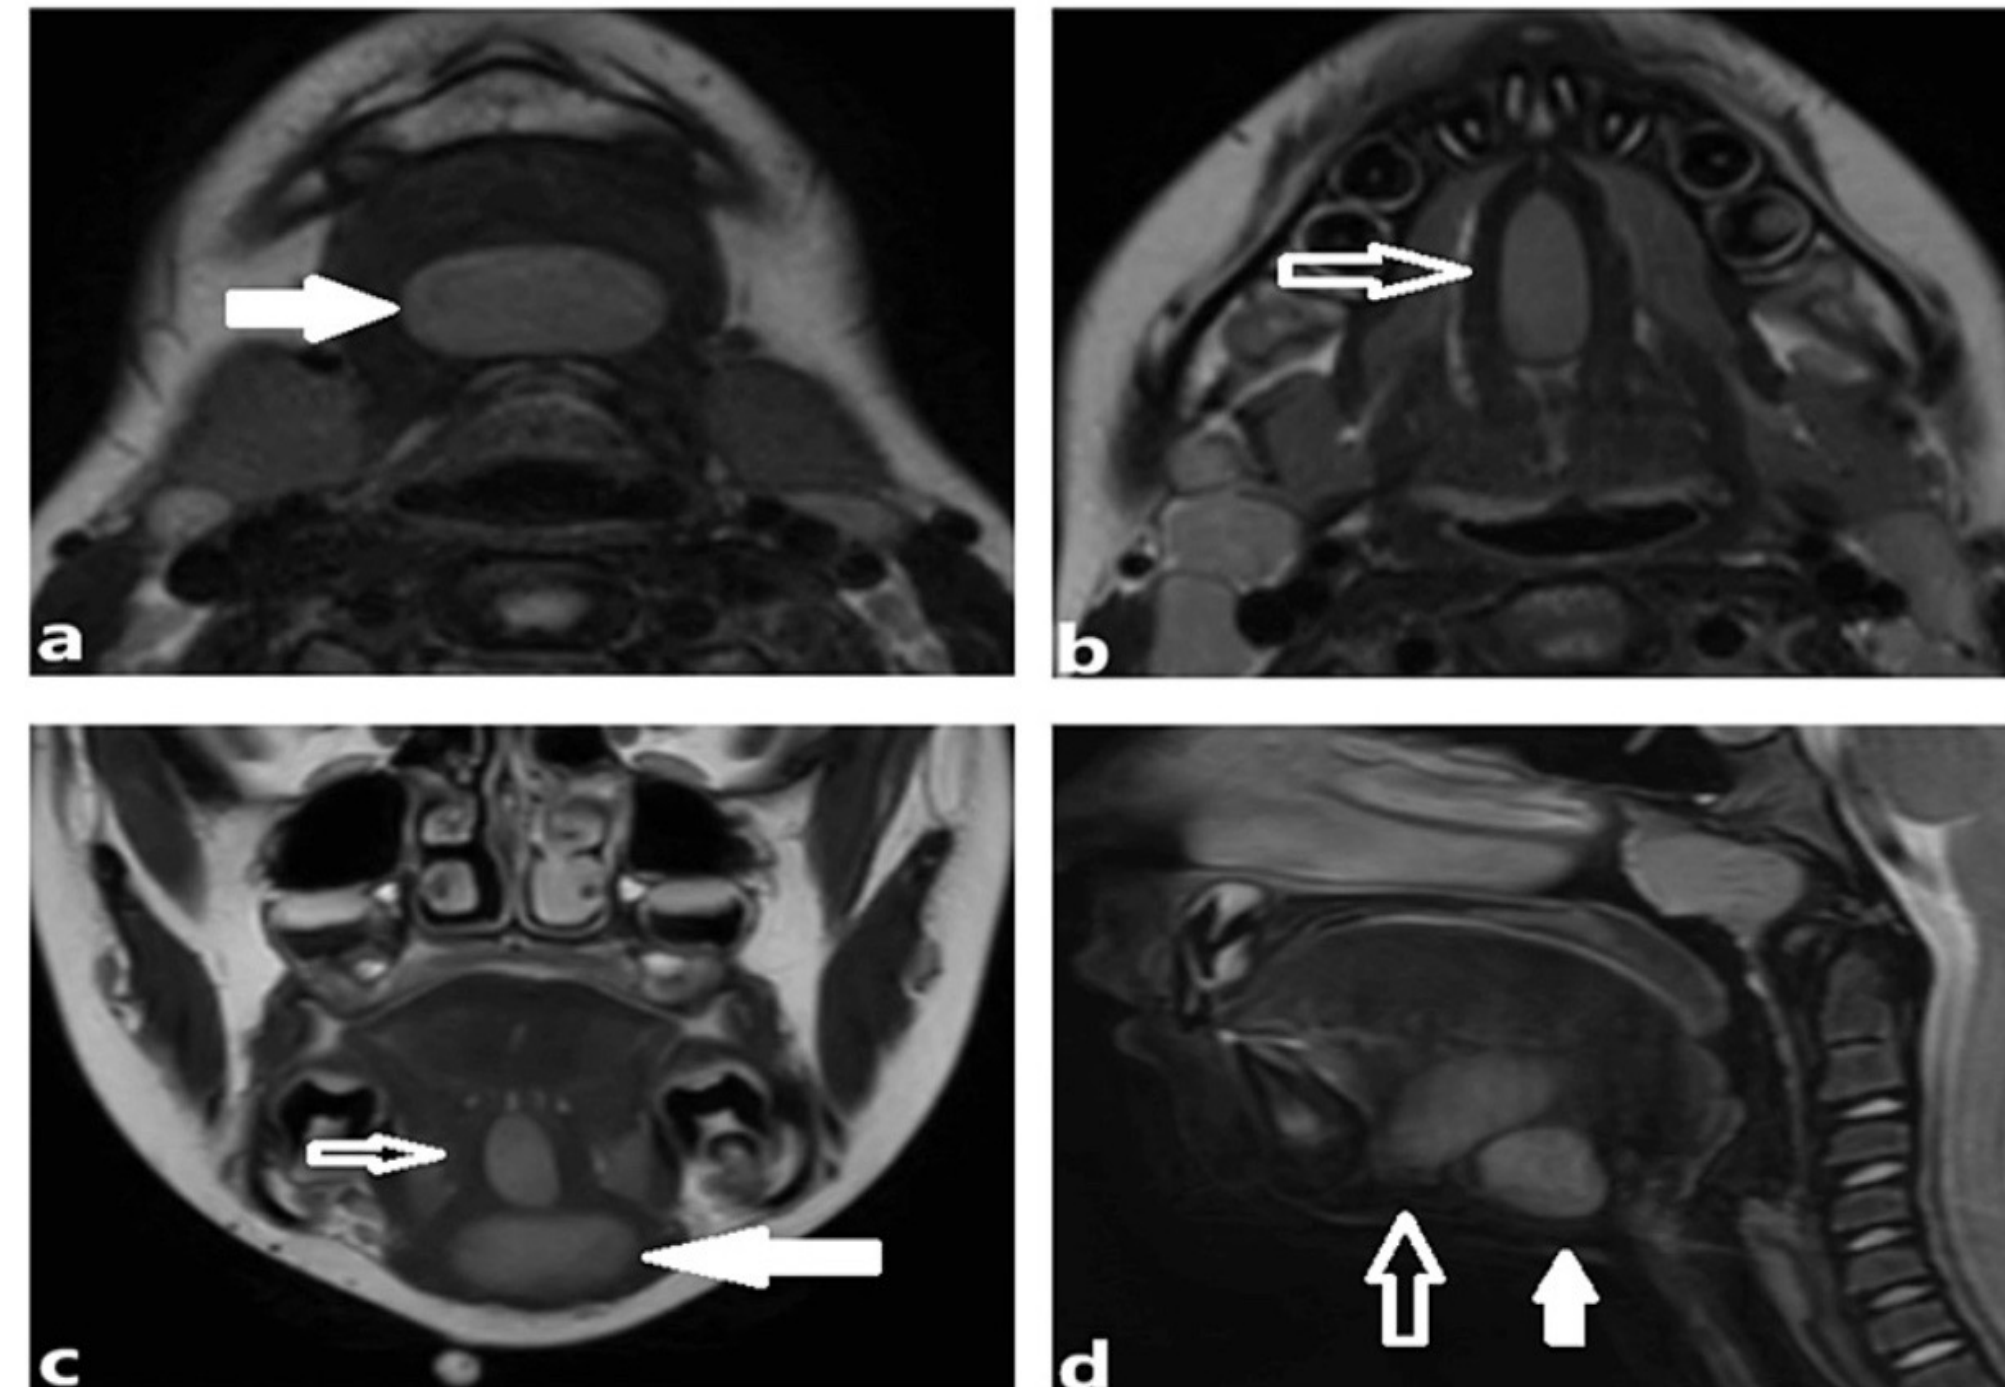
Axial T2 MRI demonstrating (a) submental space and (b) lingual masses. Coronal and sagittal T2 MRI (c & d) demonstrating relative positions of both lesions (submental space mass: solid arrow, lingual mass: clear arrow).
